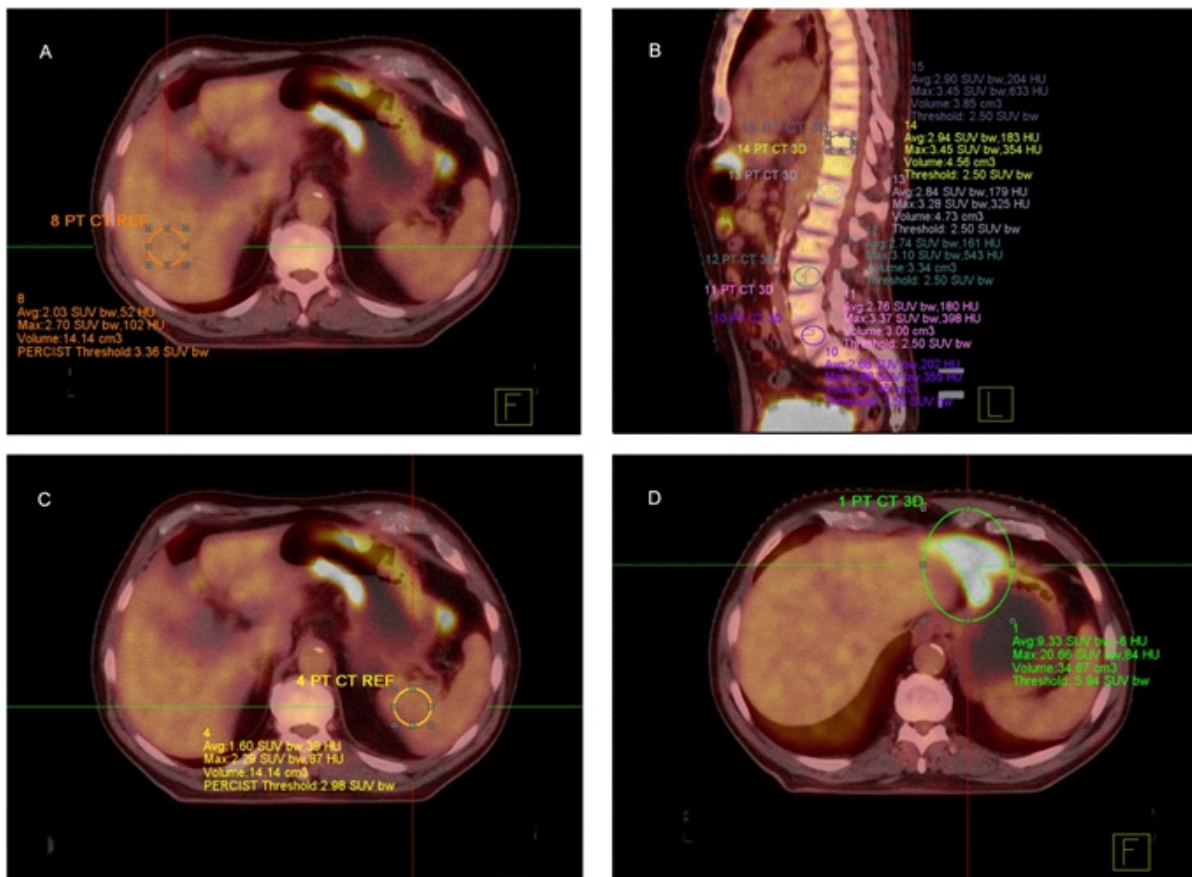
Axial scans of fused PET/CT with exemplary ROI for measuring ^{18}F -FDG uptake: A. Normal liver parenchyma; B. Thoracic/lumbar vertebrae; C. Normal spleen parenchyma; D. Primary tumor
